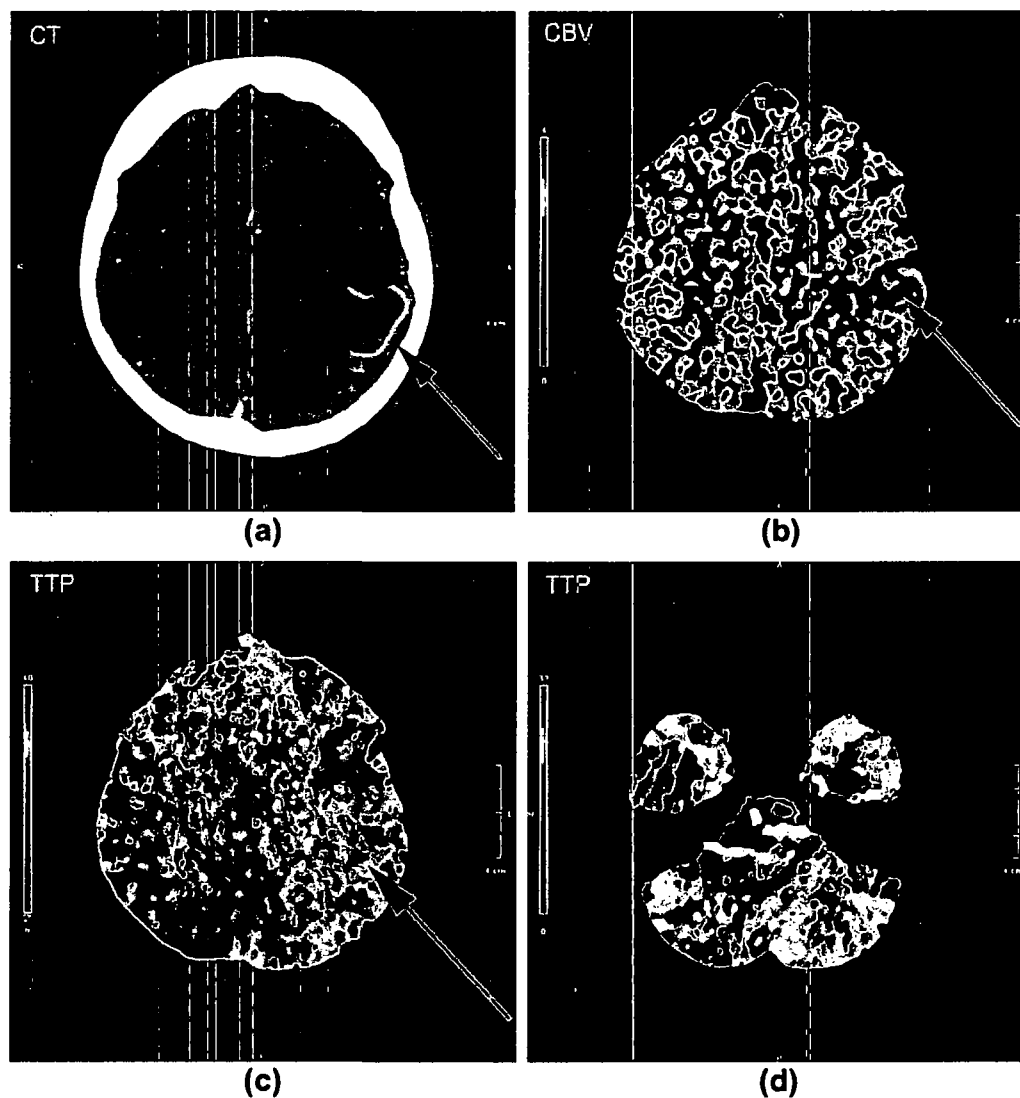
A 77-year-old man with left parietal AIS. (a) Note the dilated leptomeningeal artery, located 7.5 mm inferior to the CBV and TTP perfusion maps, indicating collateral autoregulatory response at the lateral aspect of the acute infarction in the contrast CT image (red arrow). (b) Decreased CBV and (c) prolonged TTP in the ischaemic tissue (red arrows). (d) Prolonged TTP in the contralateral cerebellar hemisphere related to the acute cerebral infarction and indicative of crossed cerebellar diaschisis.
